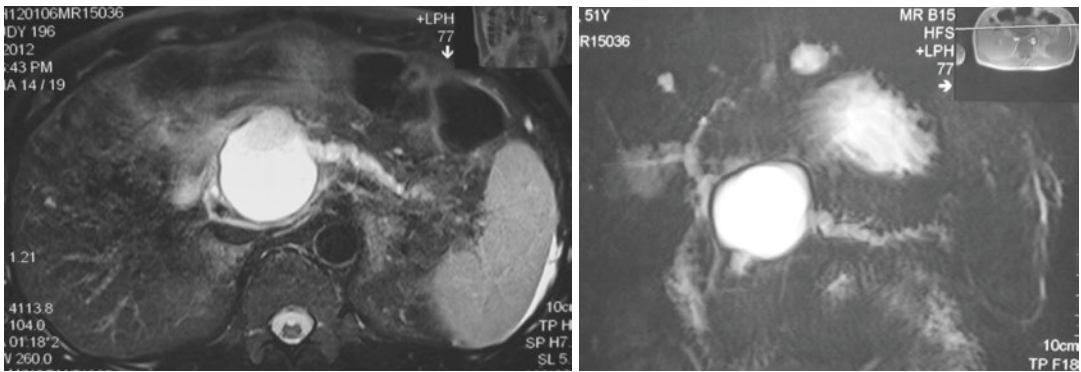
MRI and MRCP revealed significant atrophy in the pancreatic body and tail, bead-like dilatation of the main pancreatic duct, and a cystic density lesion with clearly defined margins measuring 5.6 * 4.7 cm in the pancreatic neck
